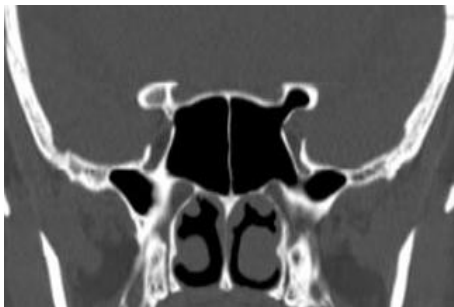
Coronal CT scan showing type 1 optic nerve on right side, type 3 on left and pneumatization of left ACP.
